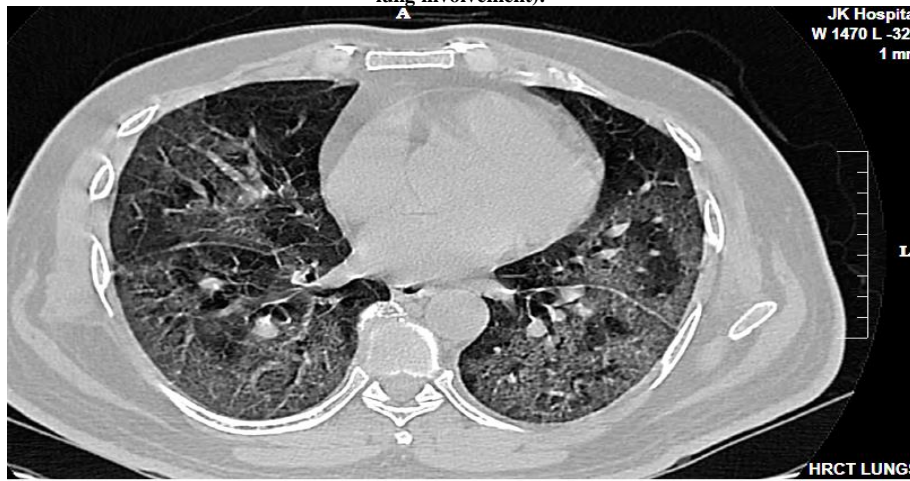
HRCT Chest of 14yr old RTPCR positive patient showing multiple confluent patches of GGO with crazy paving appearance. CT severity score; 20 (Moderate lung involvement).
